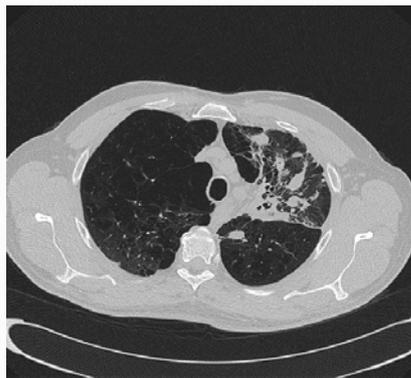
Axial thin section CT image, post-therapy.
